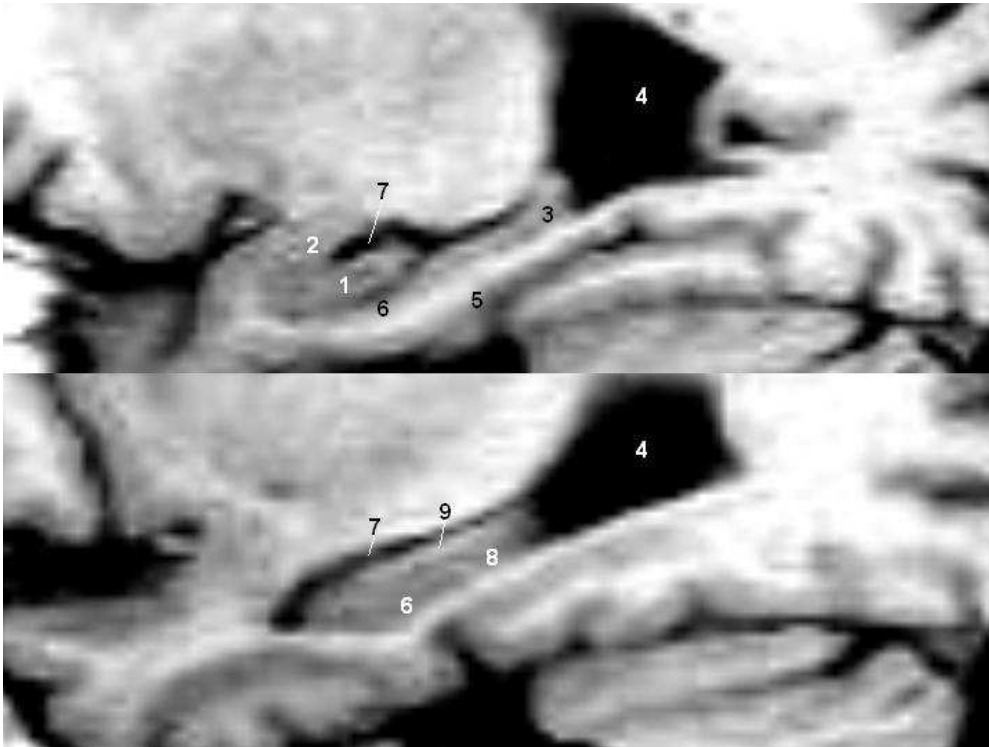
Sagittal view through hippocampus on T1-weighted MRI. Upper image is medial of lower image.
